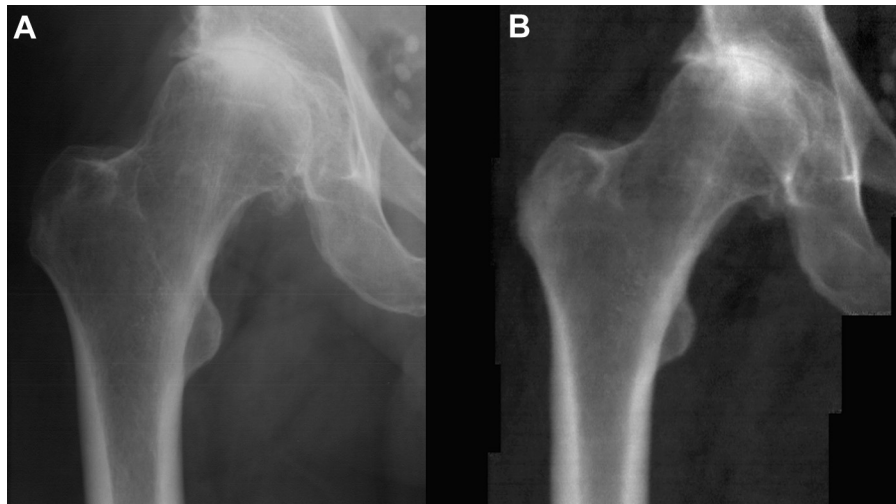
Comparison between radiograph and dual-energy X-ray absorptiometry images. (A) Plain radiograph of the hip and (B) iDXA image of the same hip. The scale and contrast of images have been adjusted for viewing purposes.
